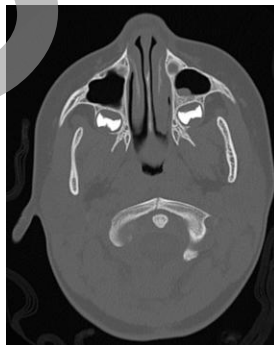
CT of Patient 1 obtained 5 months postoperatively now shows a midline well-corticated linear lucency through the C1 anterior arch consistent with a fracture, likely subacute.
